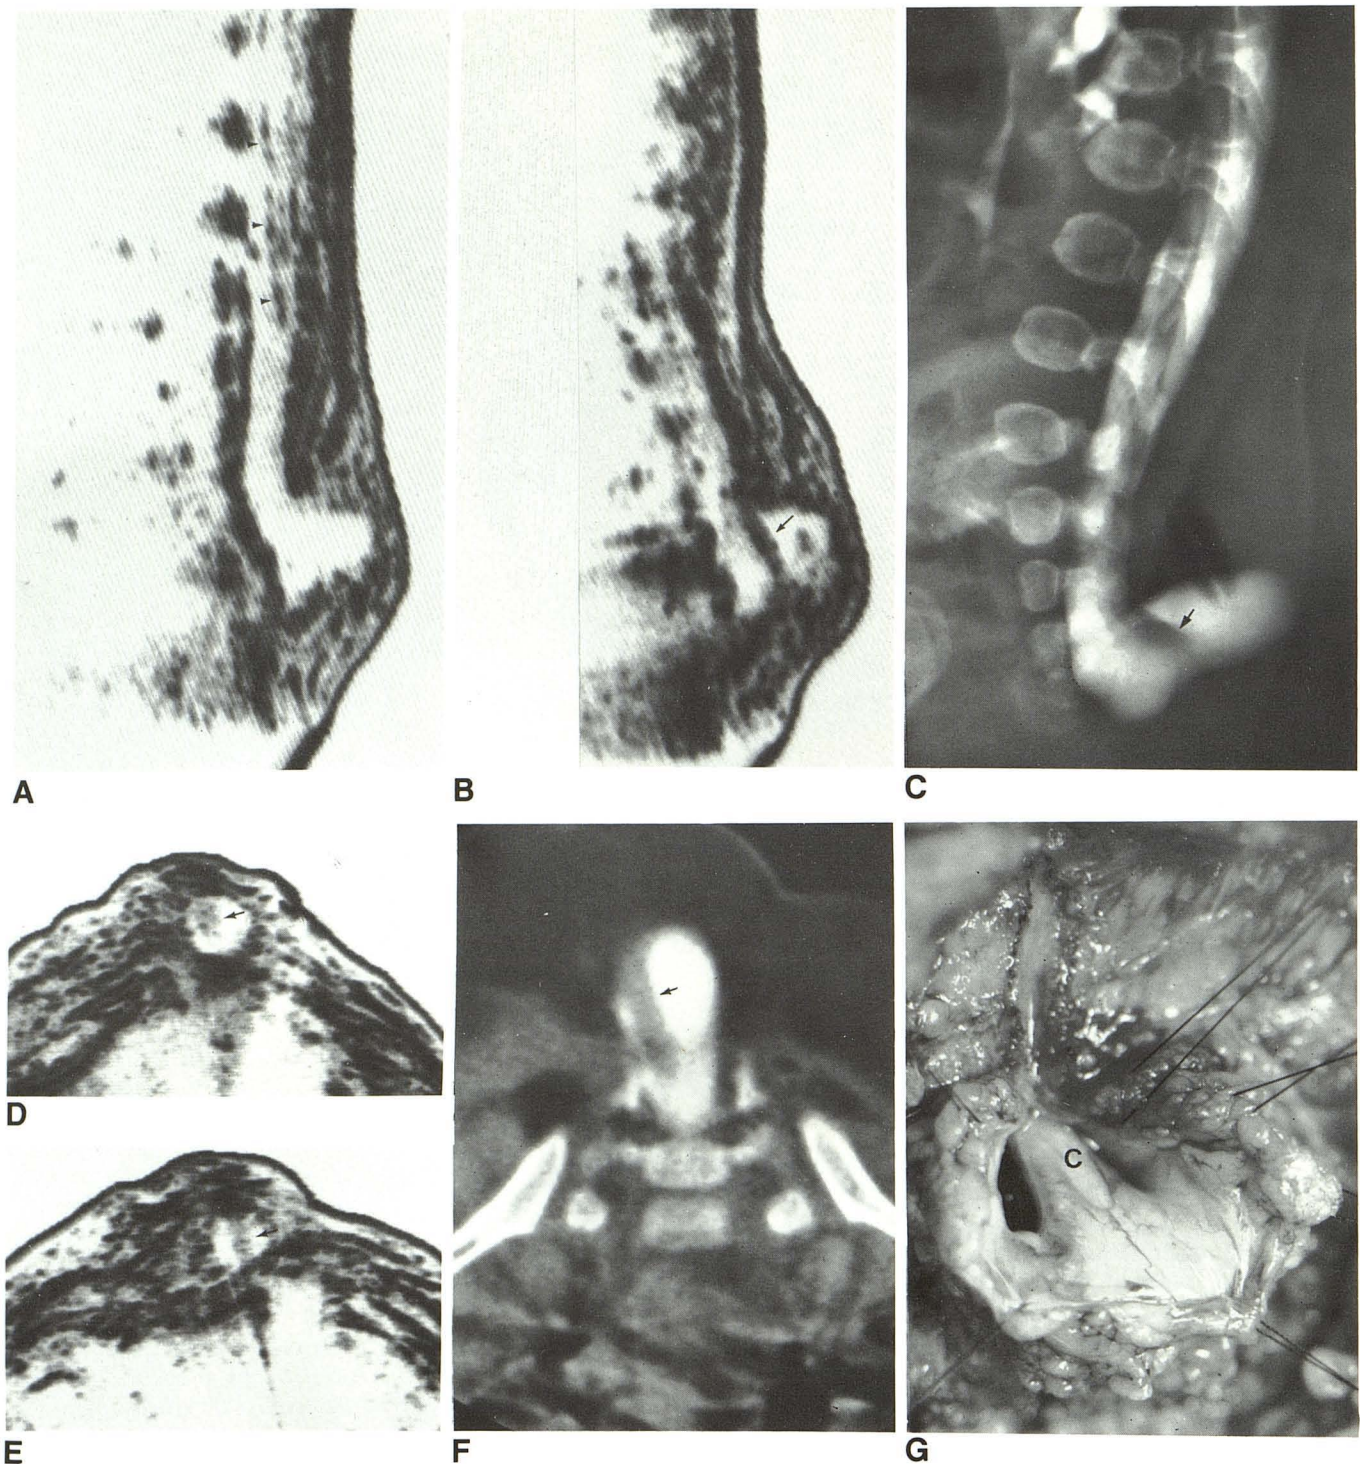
Lipomyelomeningocele with extension of filum into meningocele in 4-month-old girl with skin dimple and asymmetric skin-covered lumbosacral mass above intergluteal cleft. A and B, Sagittal sonograms reveal hyperechoic subcutaneous lumbosacral mass; large anechoic meningocele extending into mass through posterior spina bifida; "triplet" echoes from tethered spinal cord (arrowheads); and extension of hyperechoic structure (arrow) across meningocele to insert into its caudal border. C, Lateral water-soluble contrast myelogram confirms presence of subcutaneous lipoma, meningocele, and tethered cord. Lucent tubular structure (arrow) extends across meningocele
